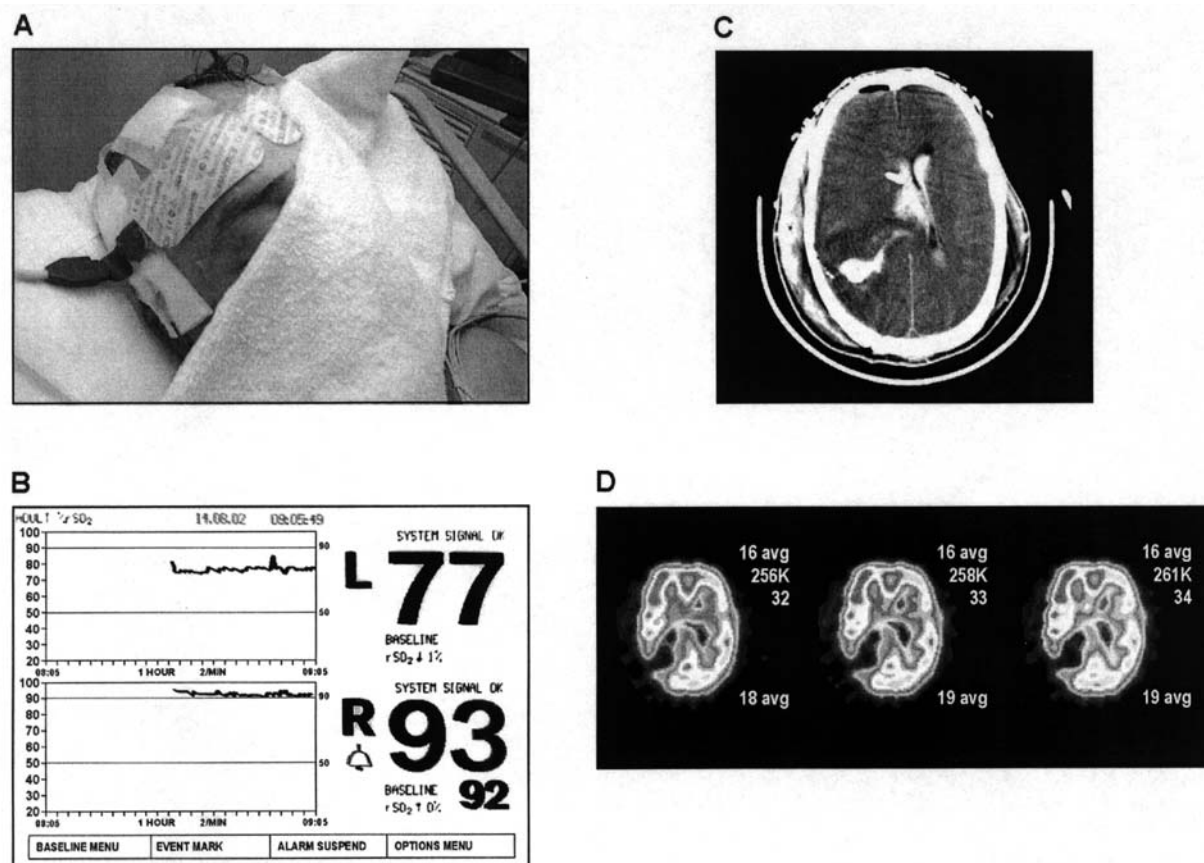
Examples of electrode placement on the forehead (A) and values of brain saturation due to mycotic aneurysm with cortical hemorrhage (B, C, D). The asymmetrical distribution of the hemorrhage seen on the computed tomography scan (C) explains (D) the left to right discrepancy on the oximetry signal (B).
